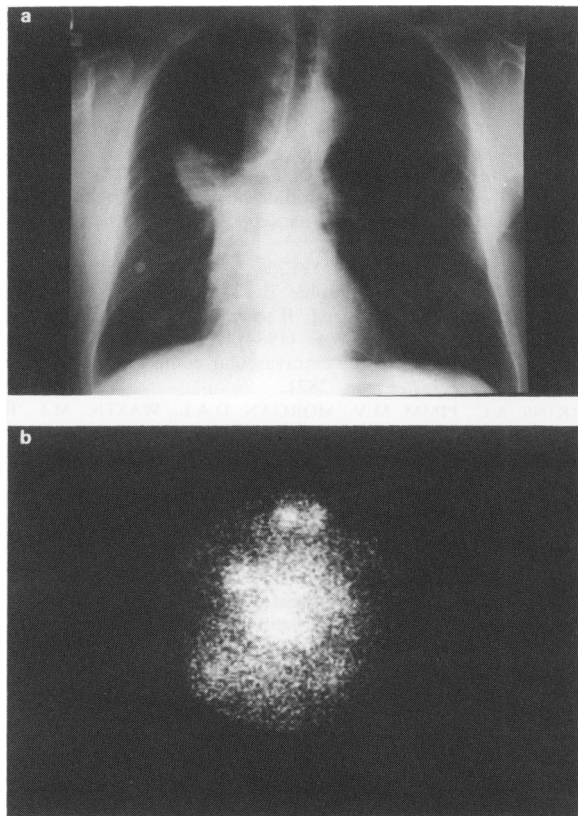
Lung carcinoma of right upper lobe. a, Chest X-ray, anterior view. b, IS of the same patient 6 days after injection of radiolabelled Po66; anterior view showing the tumour and cardiac image.
